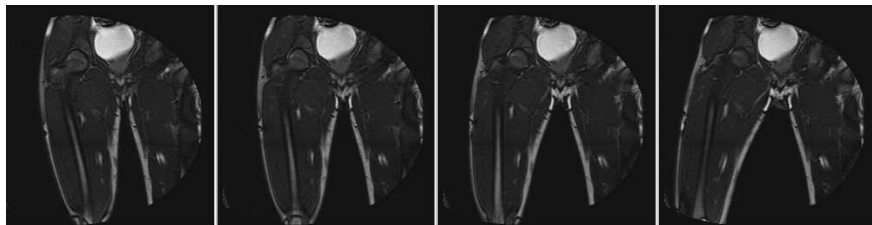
Real-time dynamic MRI of the thigh [GPMTV04]
